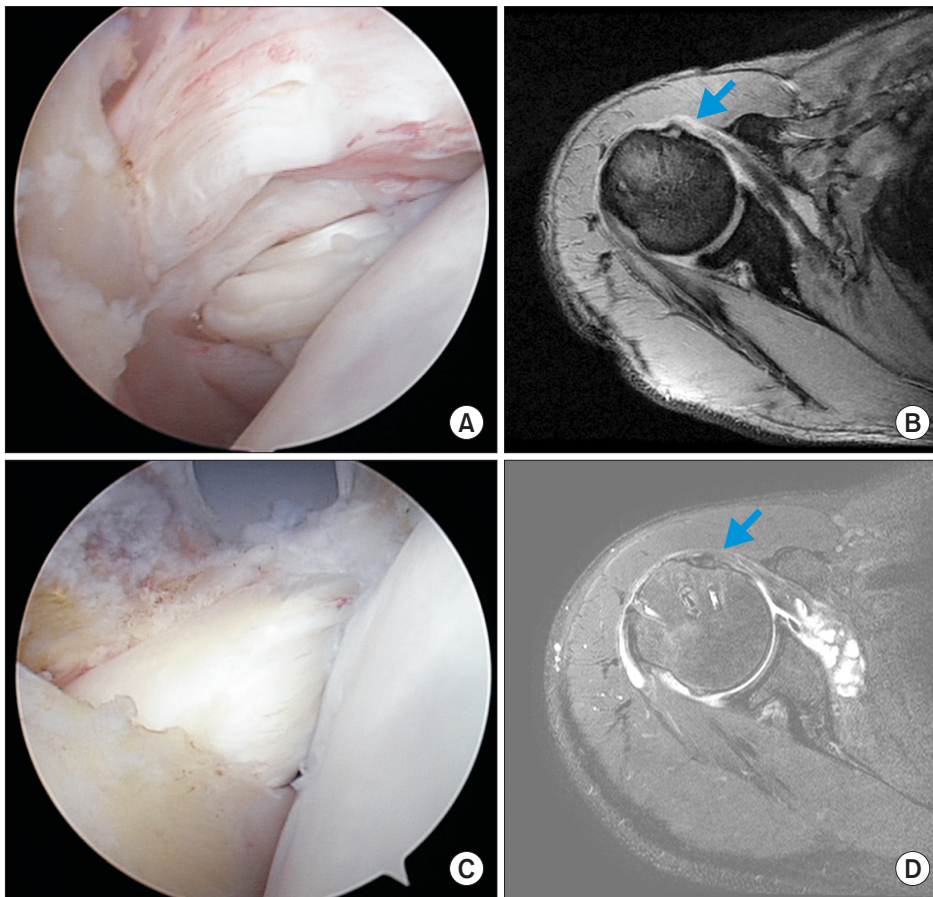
Arthroscopic images from a 62-year-old male patient. (A) A partial articular-sided tear of the upper subscapularis tendon can be seen. (B) Preoperative magnetic resonance imaging shows a subscapularis tendon tear (arrow). (C) An anatomically restored upper subscapularis tendon tear. (D) Postoperative magnetic resonance imaging shows a normal tendon (arrow).
